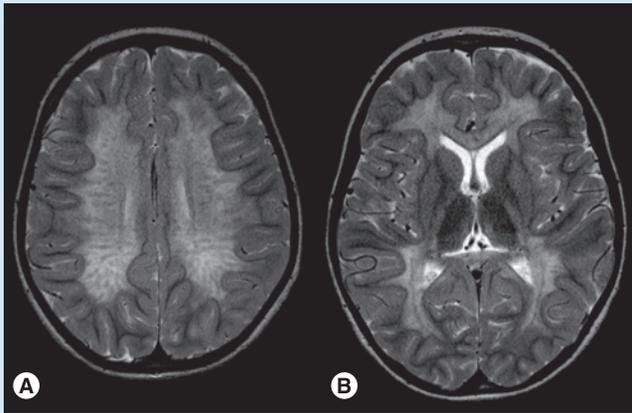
MRI in juvenile metachromatic leukodystrophy. (A) The central white matter shows signal hyperintensity and a streaky pattern, while the subcortical U fibers are spared. (B) Involvement of corpus callosum and posterior limb of internal capsule.
